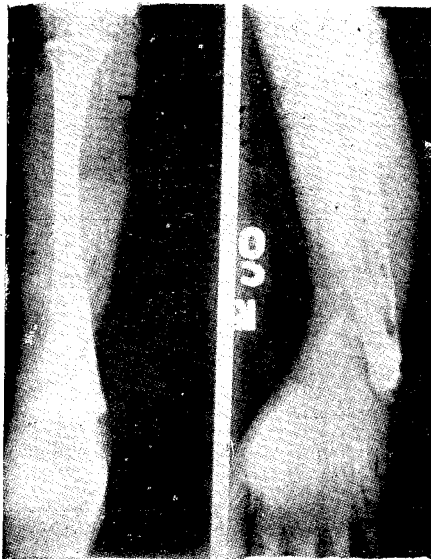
X-Ray showing fracture Dislocation of Right Radius ulna
